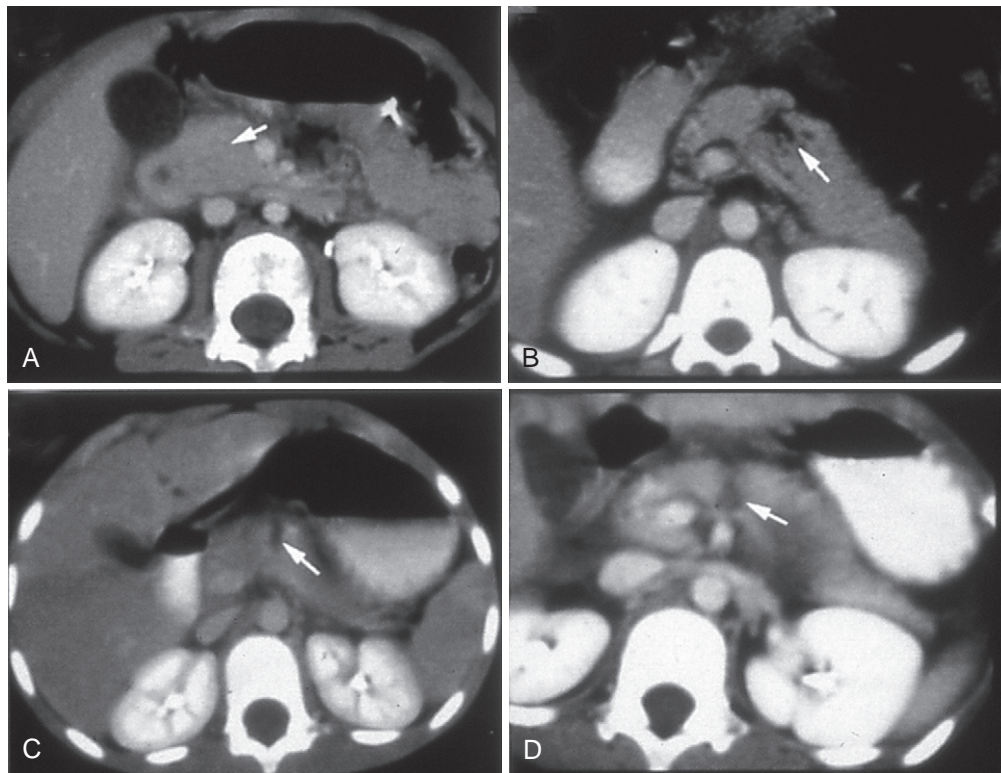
Computed tomography findings in children with pancreatic trauma. A, Contusion. B, Stellate fragmentation. C, Partial fracture. D, Transection. Arrows indicate the specific pancreatic injury.
